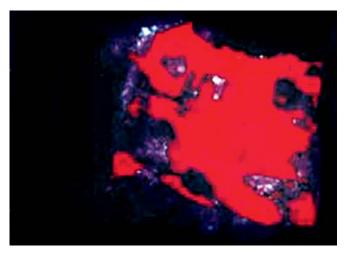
Three-dimensional power Doppler scan of a stage I ovarian carcinoma in a postmenopausal patient. Randomly dispersed vessels within irregular branching were the only finding indicating ovarian malignancy what was confirmed at the time of surgery
